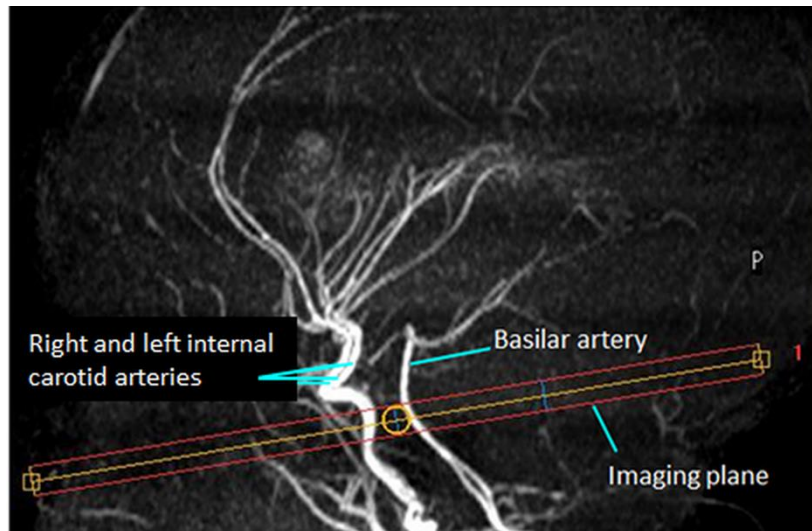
Quantification of cerebral flow: Angiogram of the left and right internal carotid and basilar arteries in a preterm infant. Yellow (centre) and red (edge) lines show the placement of a 4mm thick PC MRI sequence.
